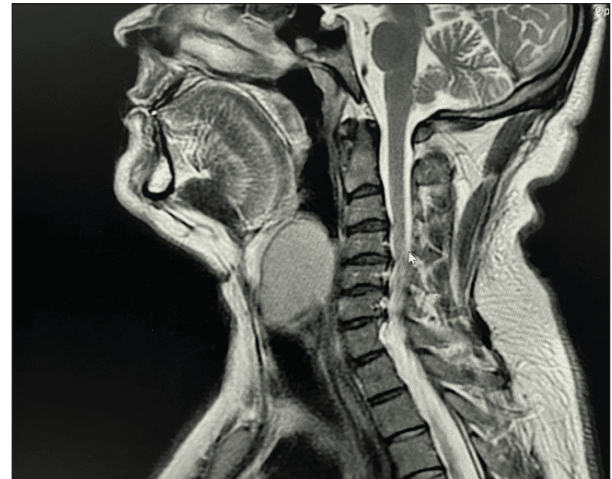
Saggital Computed Tomographic images of the neck pyocoele
